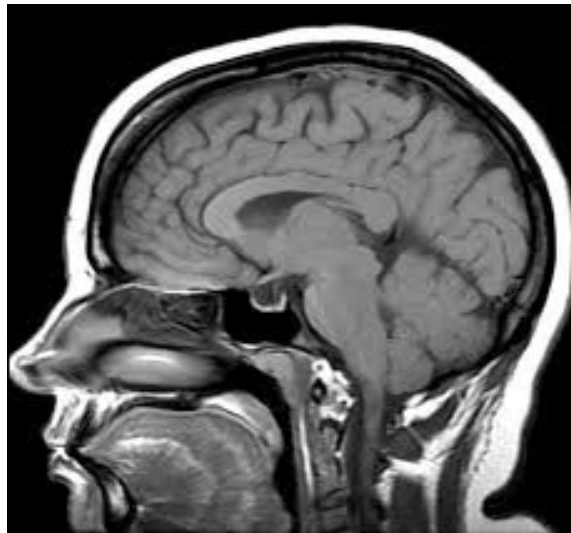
MRI of the brain, T2-weighted sagittal view of the pons
